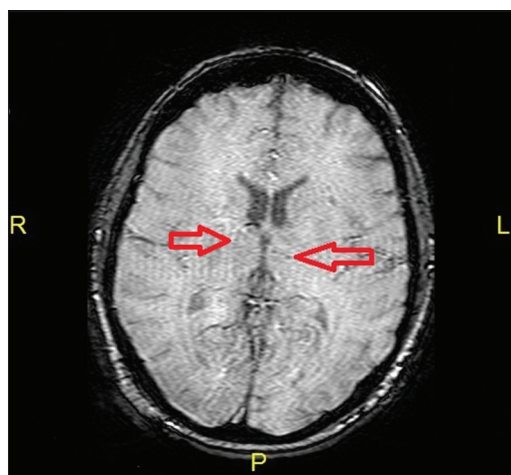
MRI brain showing microinfarcts in the basal ganglia
